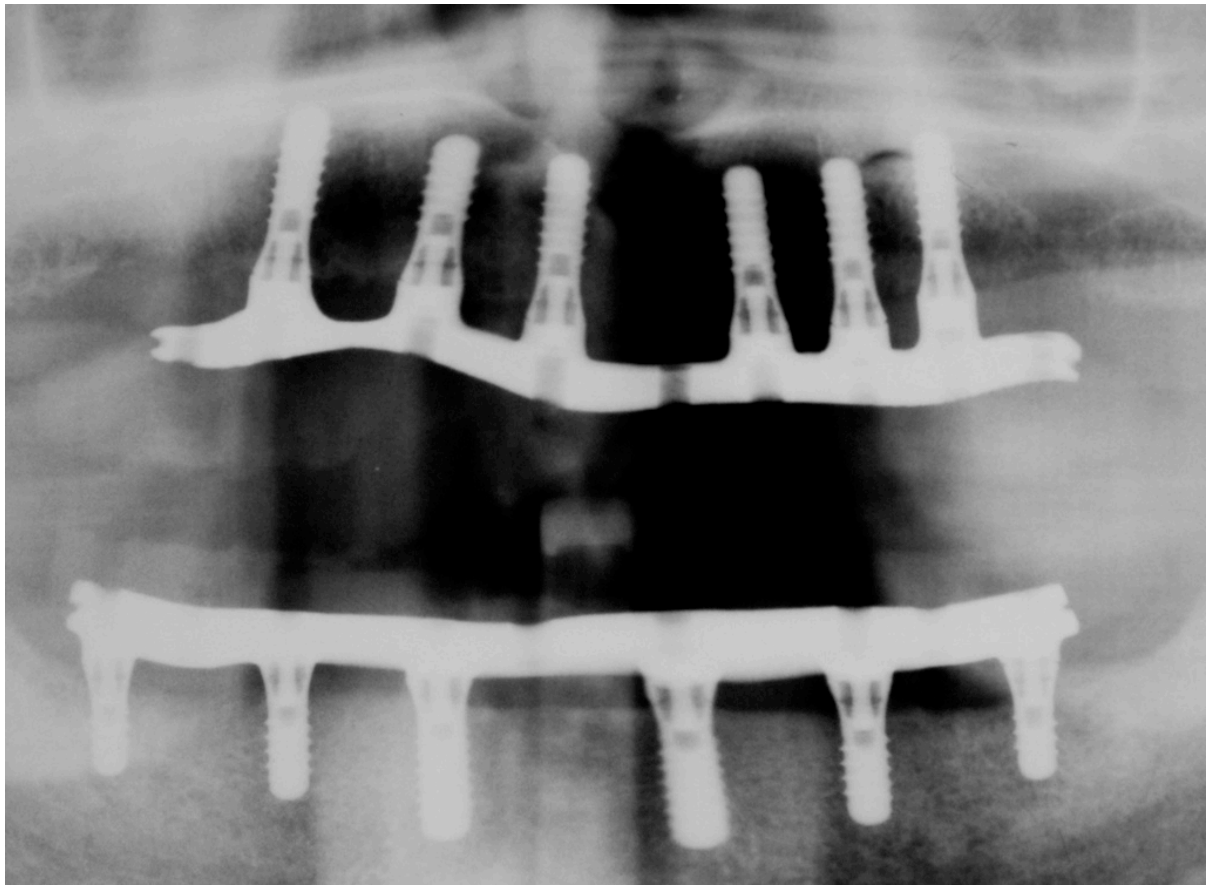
Post-insertion radiography
